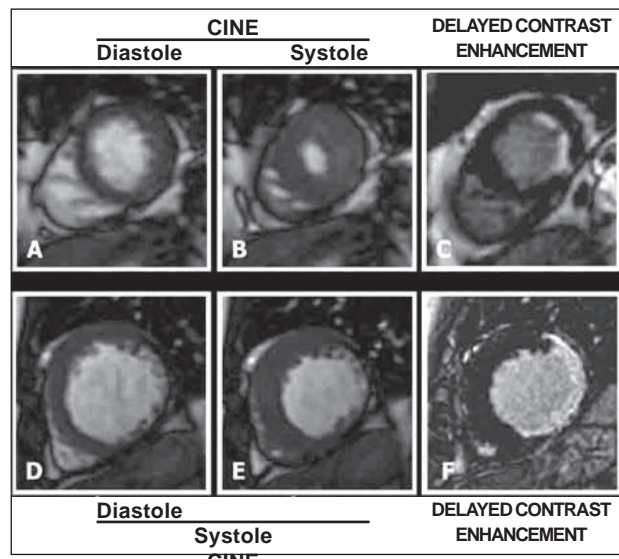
Images of cine delayed contrast-enhanced magnetic resonance imaging showing the effect of infarction extension on left ventricular function. In the upper panels, 2 images of cine-MRI are observed, 1 in diastole (A) and the other in systole (B), showing good segmentary systolic function. Both were obtained in a patient with a small subendocardial infarction of the lateral wall, observed in the delayed contrast-enhanced image to the right (C). In the lower panels, from another patient, important segmentary dysfunction of the LV lateral wall is seen in the cine-MRI images (D and E). Note the clear parietal thickening in the septal region (from panel D to panel E) and the lack of thickening in the lateral wall. In the delayed contrast-enhanced image (F), precisely in this segment, note the extensive transmural infarction of the LV lateral wall.
